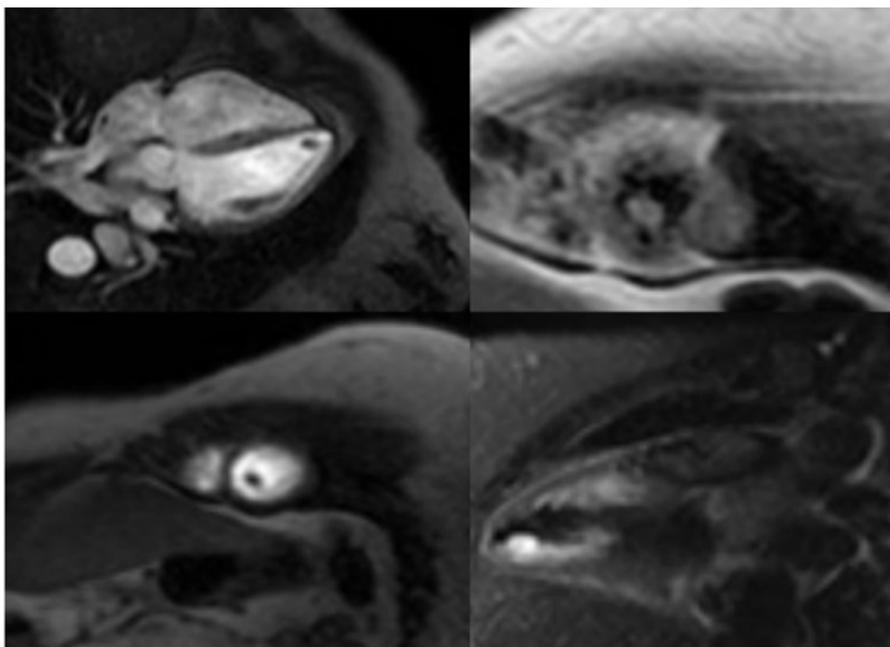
Cardiac magnetic resonance imaging (CMRI), showing a homogeneous pedunculated mass at the apex of the left ventricle, measuring 1.0 x 0.8 cm, isointense on T1 and T2, with no fat saturation and no first-pass perfusion, showing late peripheral enhancement “in a peripheral halo”.
